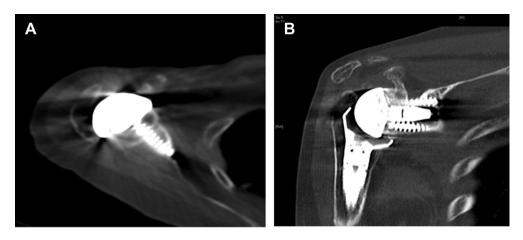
(A) Axial and (B) coronal computed tomographic views showing intact bone graft and complete peg intergation and bone graft incorporation at a 2-year interval.
